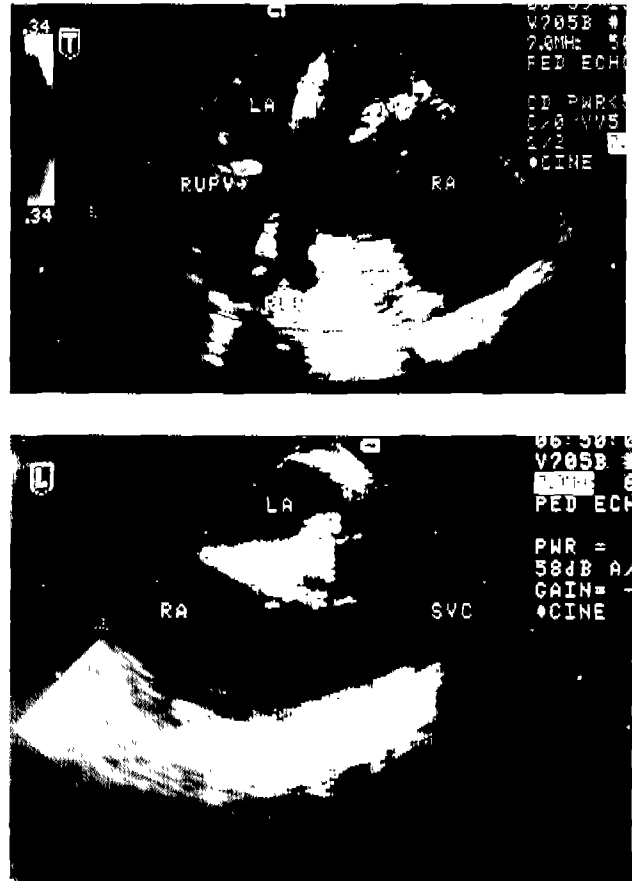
Postoperative transesophageal echocardiography in Patient 1. A. Anomalous pulmonary vein is redirected through intra-atrial baffle into LA. B. Widely patent reconstructed cavaatrial pathway.
